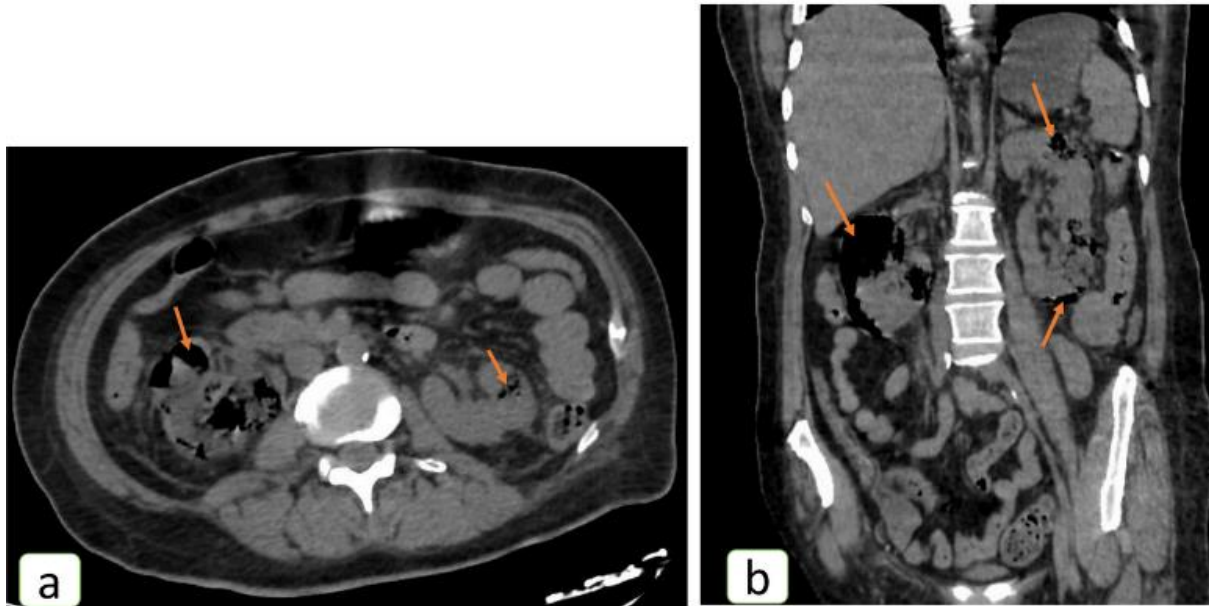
Abdominal and pelvic CT no enhanced scan in axial section (a) and coronal reconstruction (b), in a 62-year-old woman followed for type 2 diabetes, admitted to the emergency room in a state of shock; showing the presence of gas (arrows) in the right and left renal parenchyma posing the diagnosis of emphysematous pyelonephritis of stage 4.
